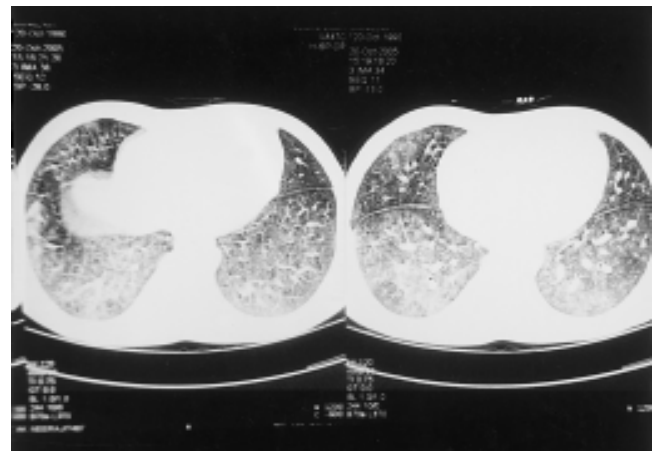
CT scan showing lower section
